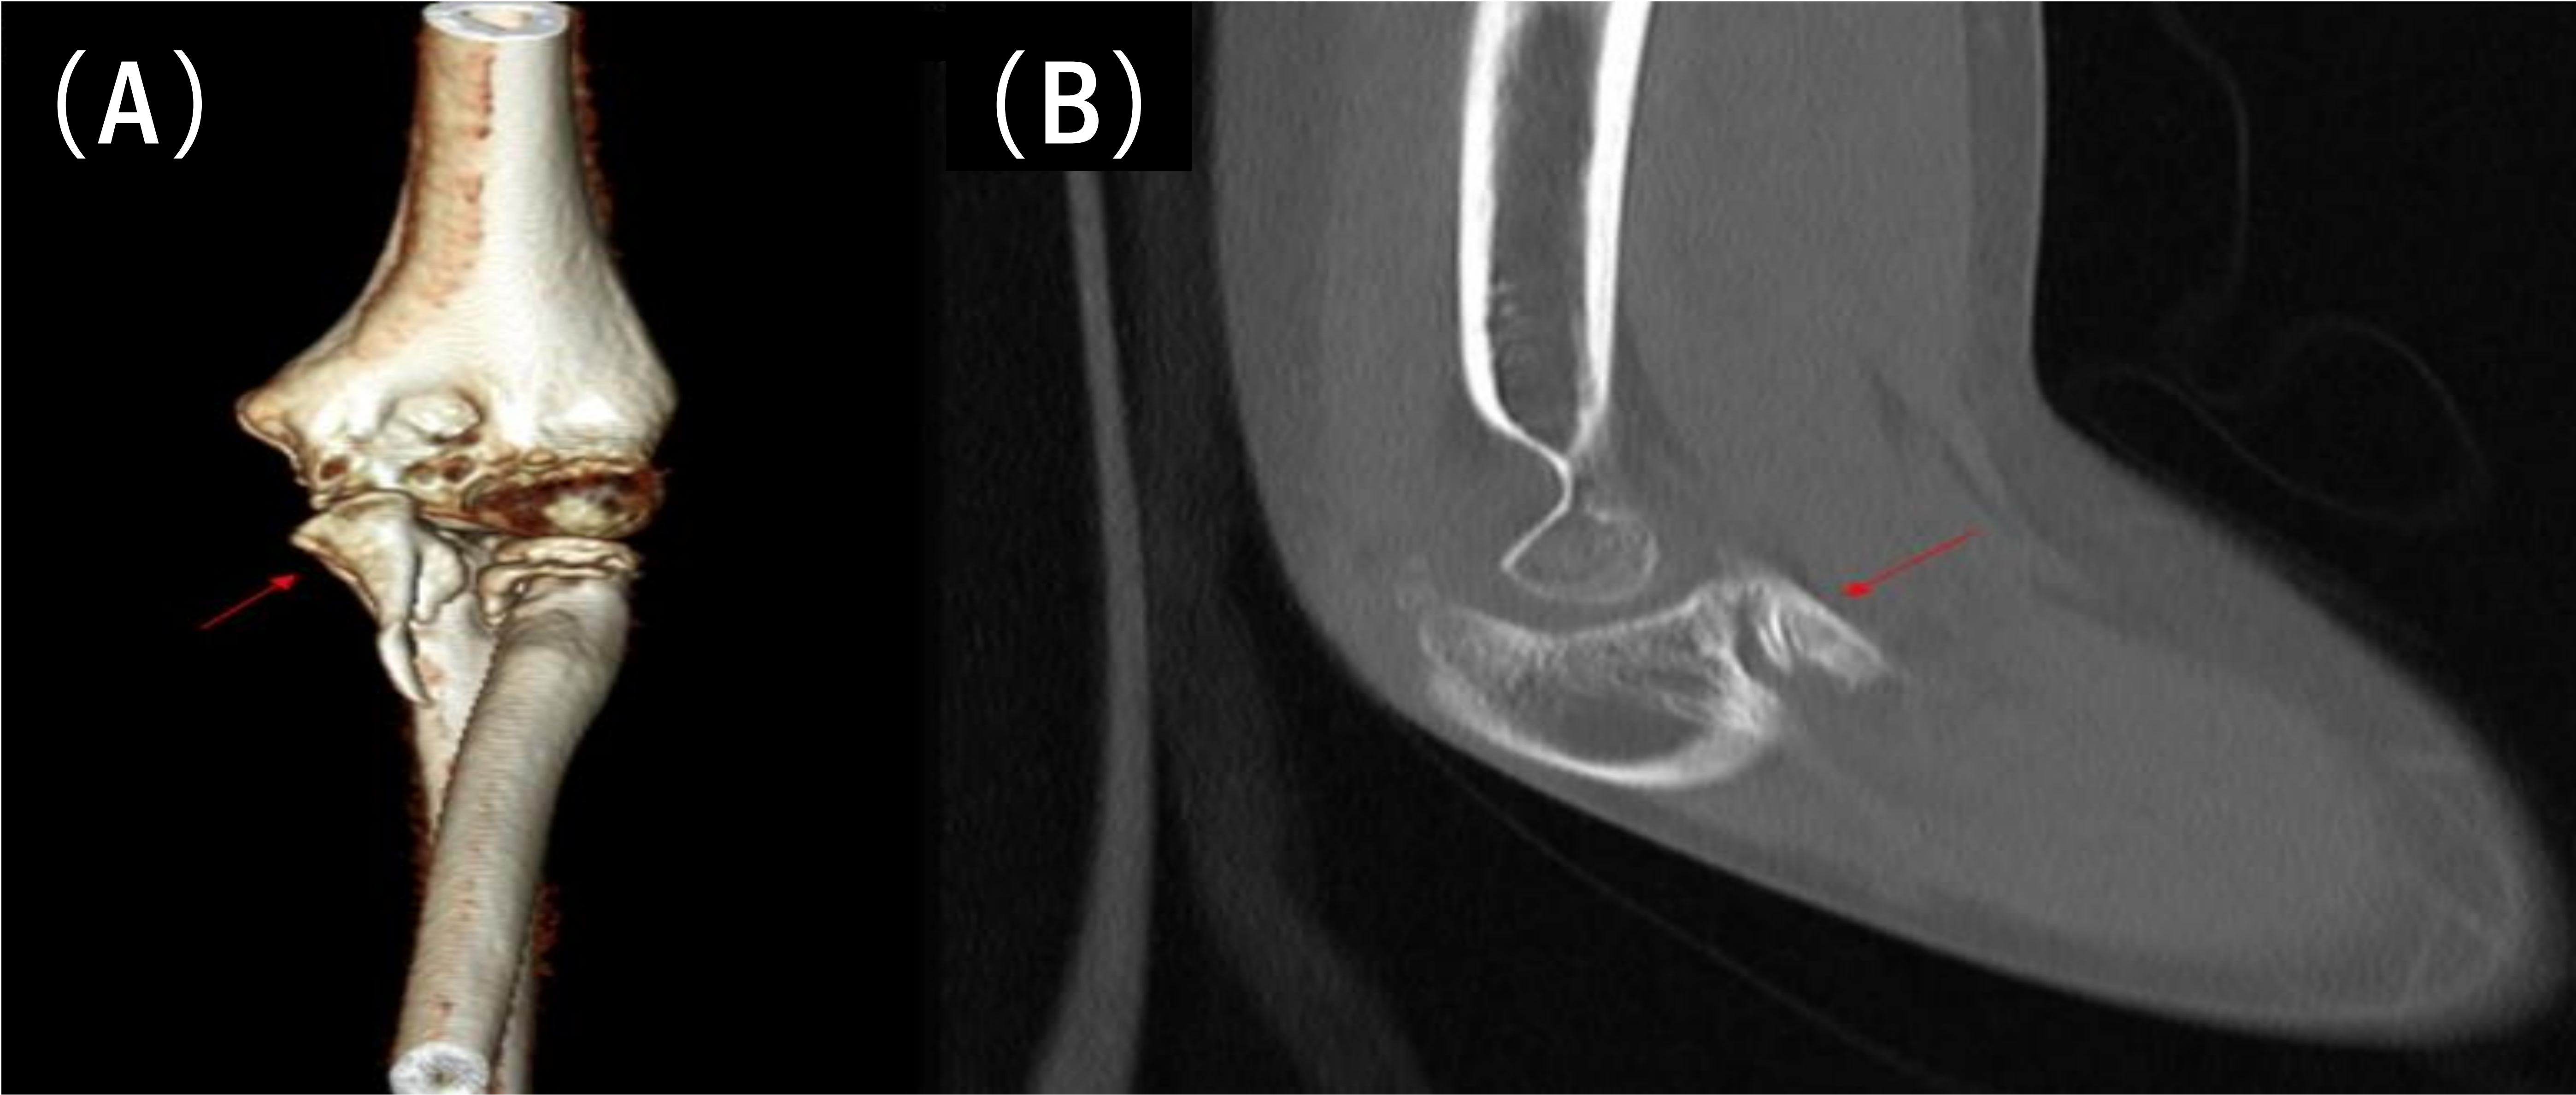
CT scan of the left elbow. (A) 3-dimensional CT scan revealed HO at the anterior aspect of the ulna and medial aspect of the radial head (arrow). (B) The sagittal view of the CT scan revealed HO (arrow).
